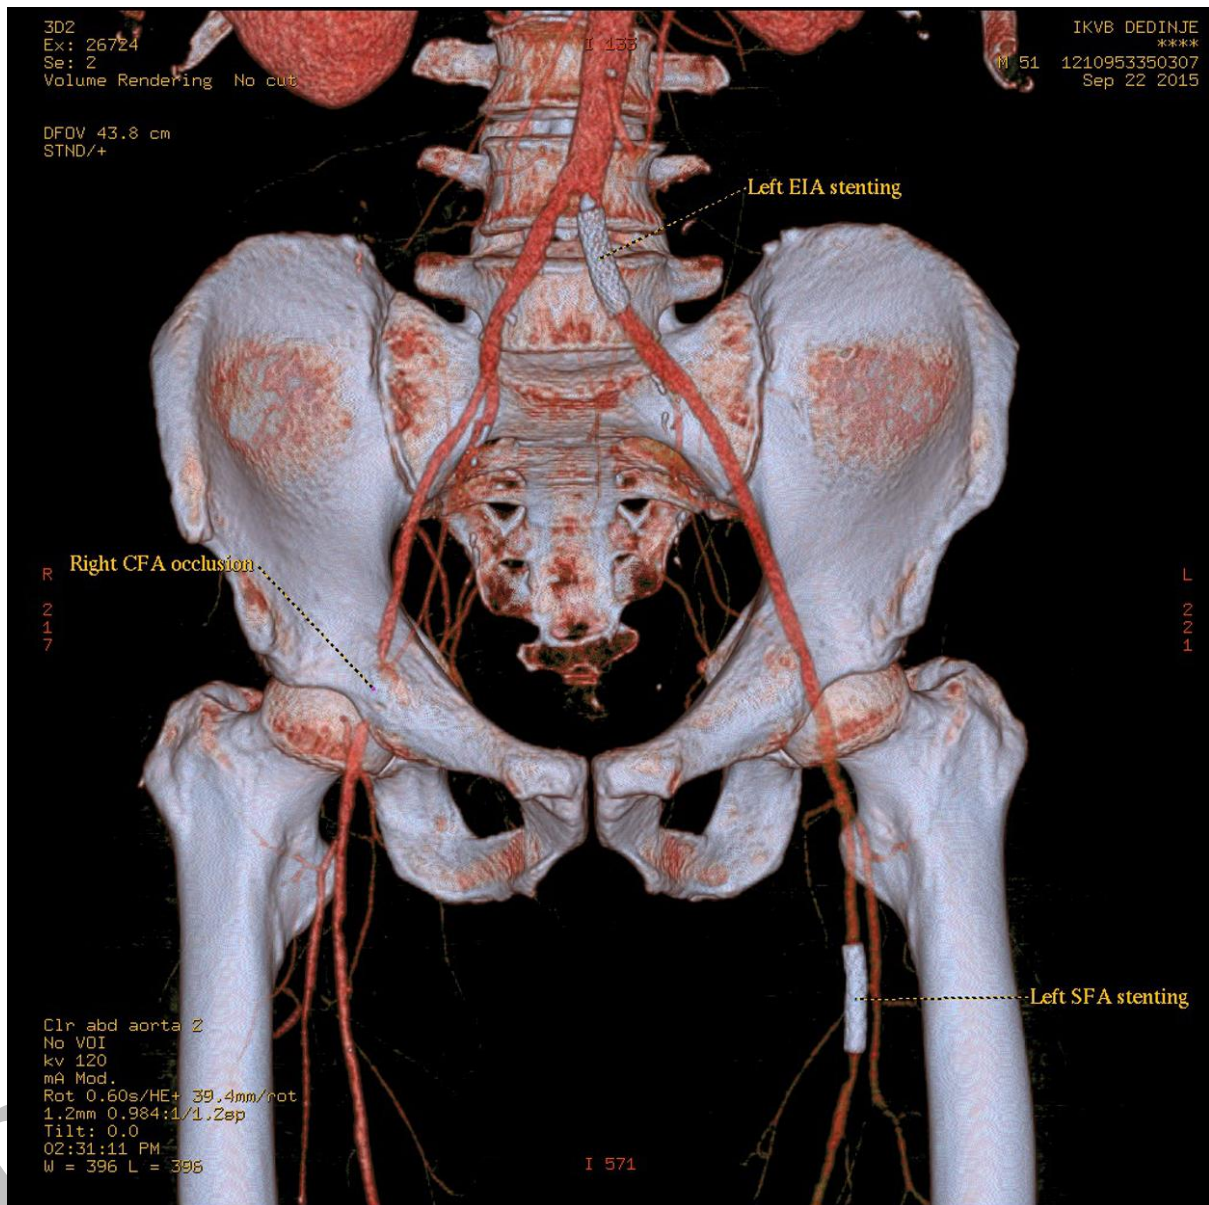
Multidetector computed tomography angiography; regular findings after left common iliac artery and superficial femoral artery (SFA) angioplasty with stent placement and evident right common femoral artery (CFA) occlusion – posterior/anterior view
